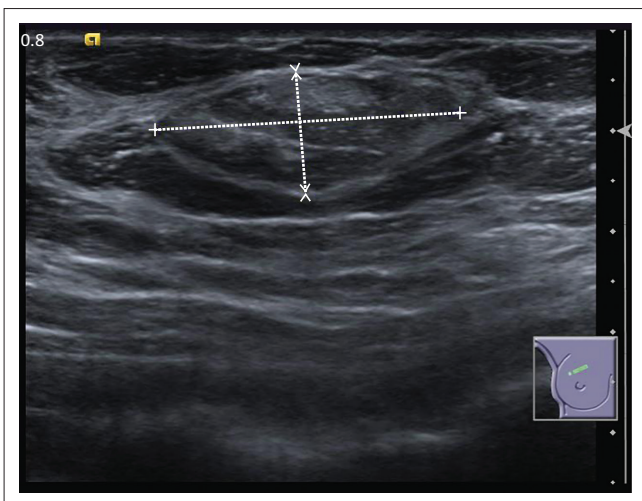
Ultrasound image at the 12 o'clock position of the right breast demonstrates a well-defined oval lesion with a mixed echogenic pattern.
